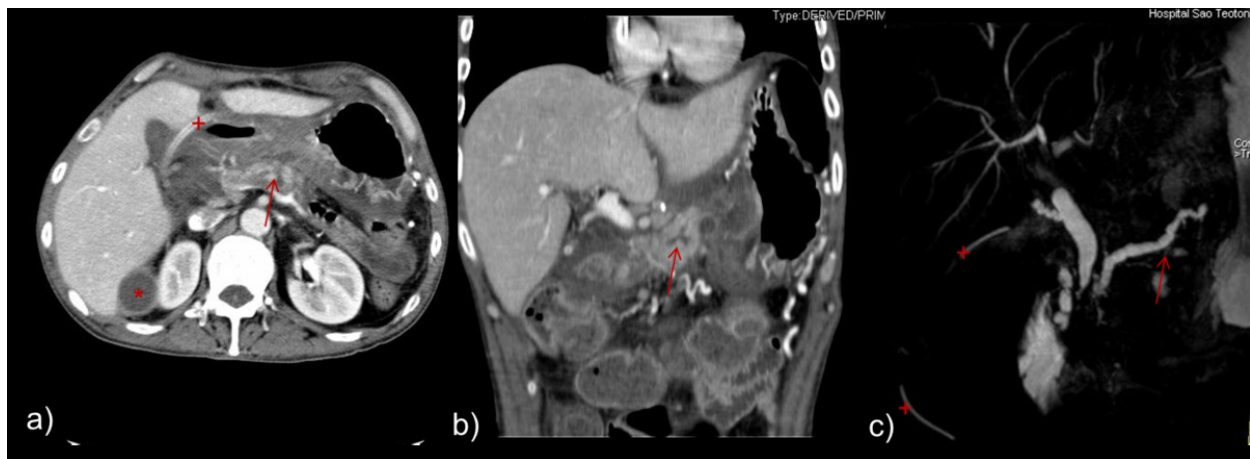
axial and coronal enhanced CT images a) b) and coronal oblique MIP MRCP image c) of a patient with ascites and history of pancreatitis in whom a focal discontinuity of the main pancreatic duct was observed at the pancreatic body (arrows) corresponding to a fistula. In the image an external drain (+) a collection posterior to the right lobe of the liver (*) can be appreciated.
